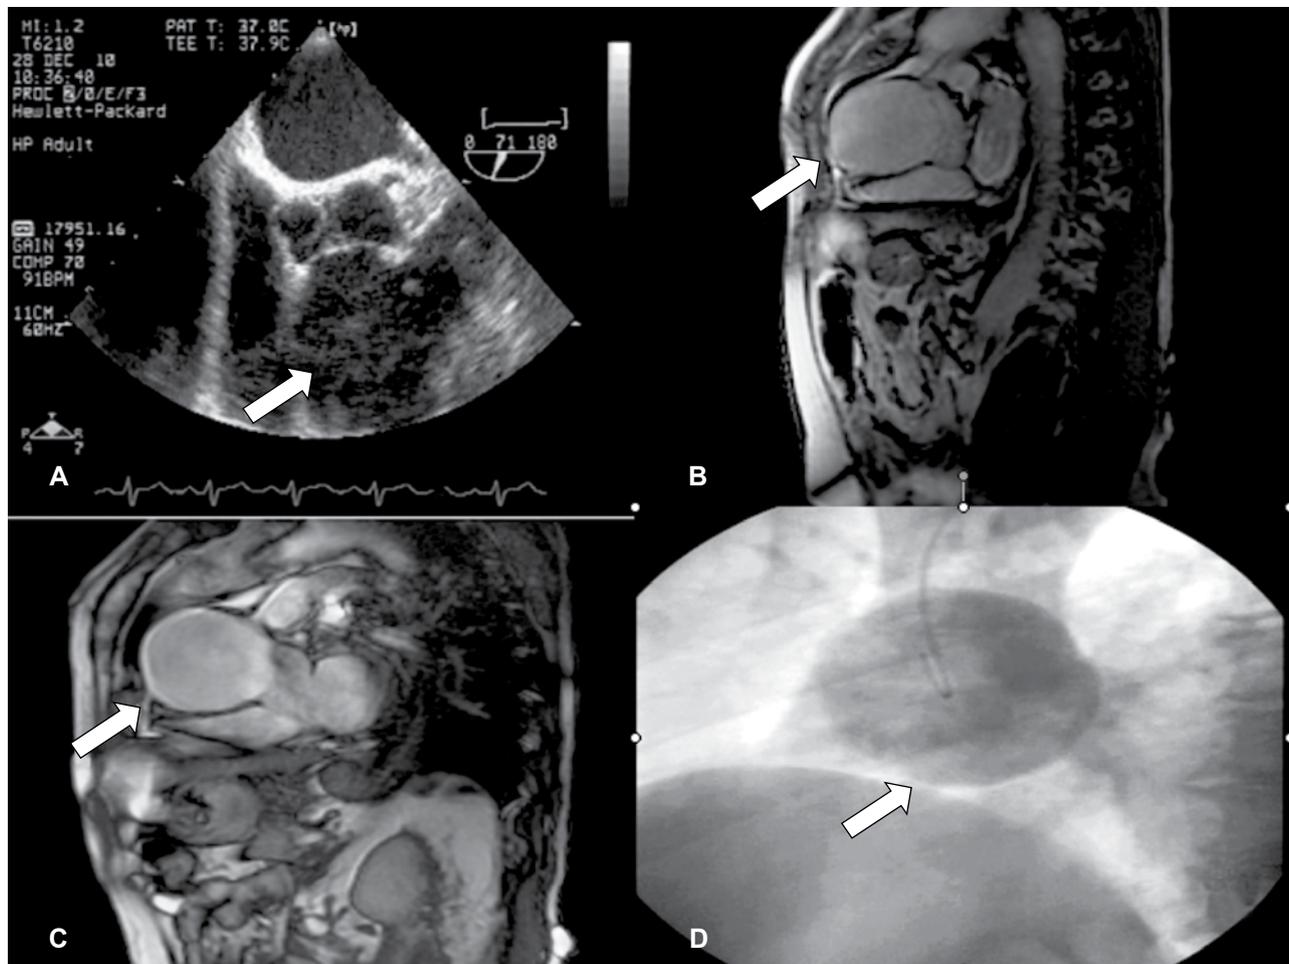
Transesophageal echocardiography showed a large mass in close relation to the right coronary sinus (A). Magnetic resonance imaging revealed the existence of a large aneurysm originating from the right sinus of Valsalva (B,C). Coronary angiography again showed the abovementioned aneurysm, but delineation of the right coronary artery was not feasible because of the size of the aneurysm (D).
